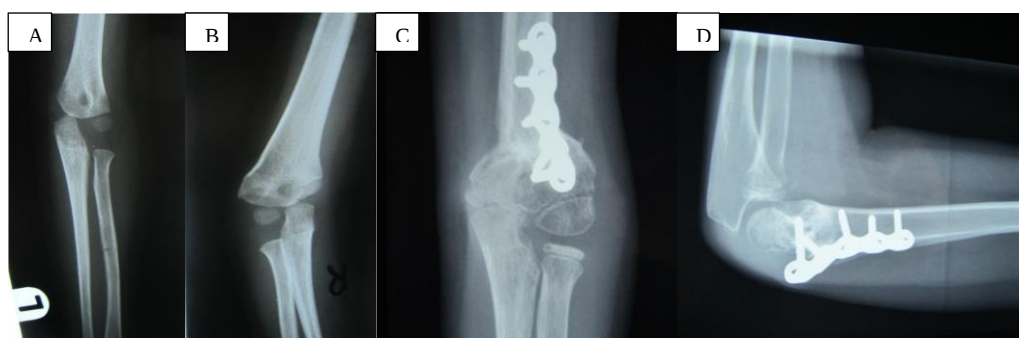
A) Preoperative anteroposterior (AP) elbow radiograph demonstrating persistent cubitus varus with medial trochlear irregularity before corrective osteotomy; B) Preoperative lateral radiograph showing a fixed flexion posture with preserved ulnohumeral congruity; C, D) Post-operative AP and lateral radiograph following lateral extension valgus osteotomy fixed by plate
